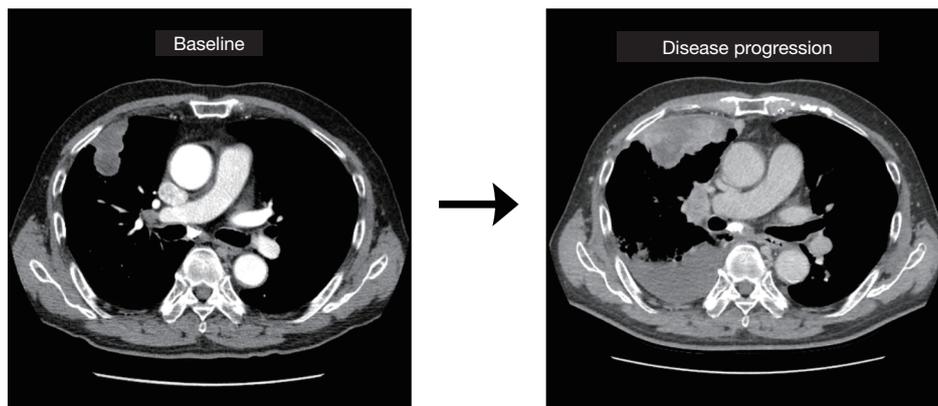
Representative CT images at baseline and disease progression in response to capmatinib.
